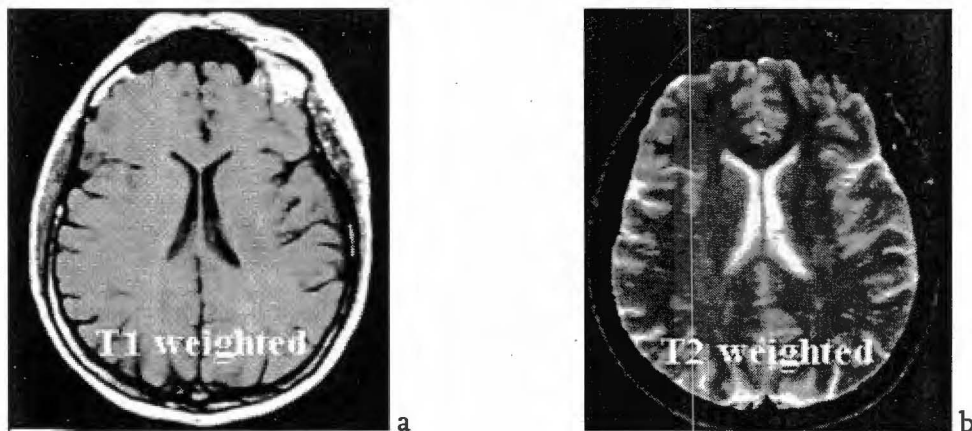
Comparison of T_1 - (a) and T_2 -weighted (b) MR images of the brain. [52].
